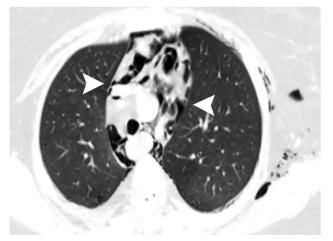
Computed tomography shows pneumomediastinum (arrowheads).
